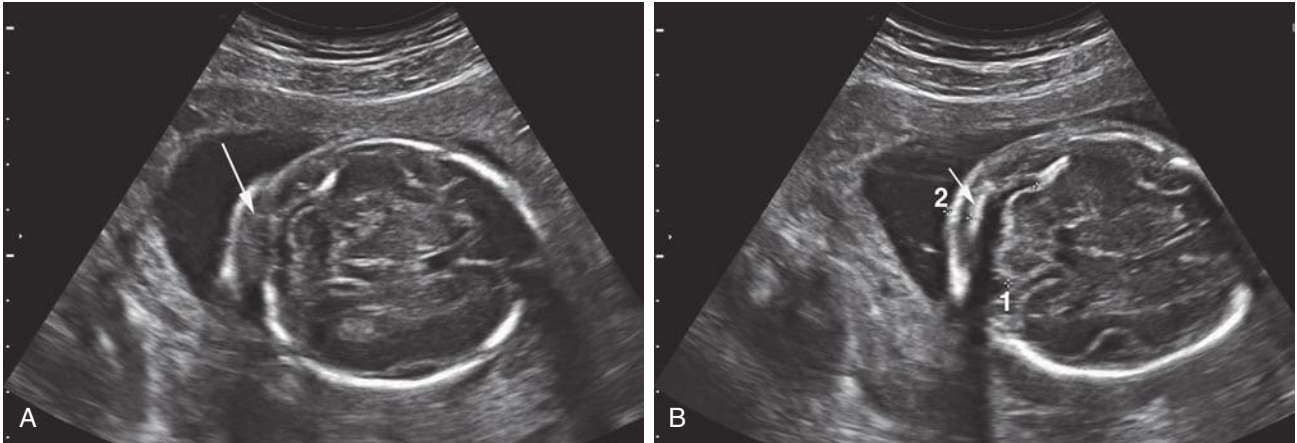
A, Transverse axial plane of section of the fetal head at 20 weeks' gestation. The nuchal fold area (*arrow*) appears abnormally prominent. B, Normal appearance of the nuchal fold in the same fetus. To accurately measure the nuchal fold the posterior surface of the occipital bone should be imaged (*arrow*). This can often be achieved by scanning from a 30-degree occipital direction. (From Cho JY, Kim KW, Lee YH, Toi A: Measurement of nuchal skin fold thickness in the second trimester: influence of imaging angle and fetal presentation. *Ultrasound Obstet Gynecol* 25:253-257, 2005.)
